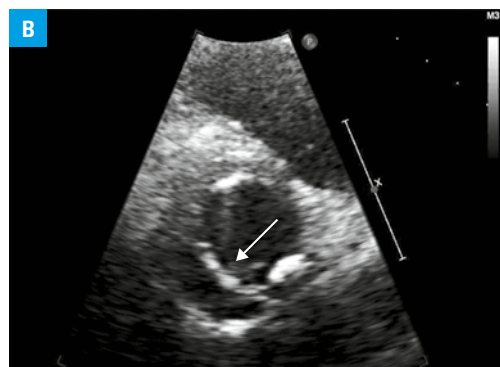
A – ascending aortic dissection (transthoracic echocardiography, parasternal long-axis view); B – ascending aortic dissection (transthoracic echocardiography, parasternal short-axis view); C – aortic insufficiency (transthoracic echocardiography, apical 4-chamber view, color Doppler mode)
